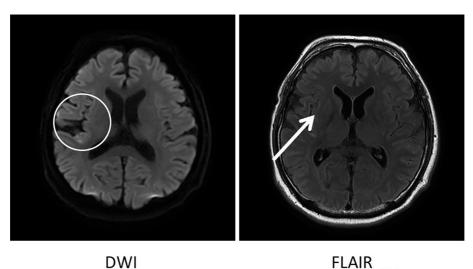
Magnetic resonance imaging findings at admission. High intensities in the right temporal lobe on DWI (circle) and high-intensity areas in the sulcus of the cerebral hemisphere on FLAIR imaging (arrow), indicating bacterial meningitis. DWI: diffusion-weighted imaging, FLAIR: fluid-attenuated inversion recovery
